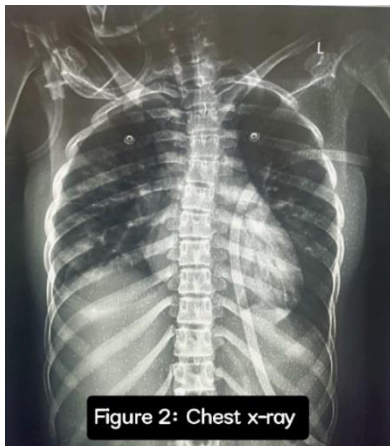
Chest X-ray displaying perihilar shadows accompanied by cardiomegaly.
